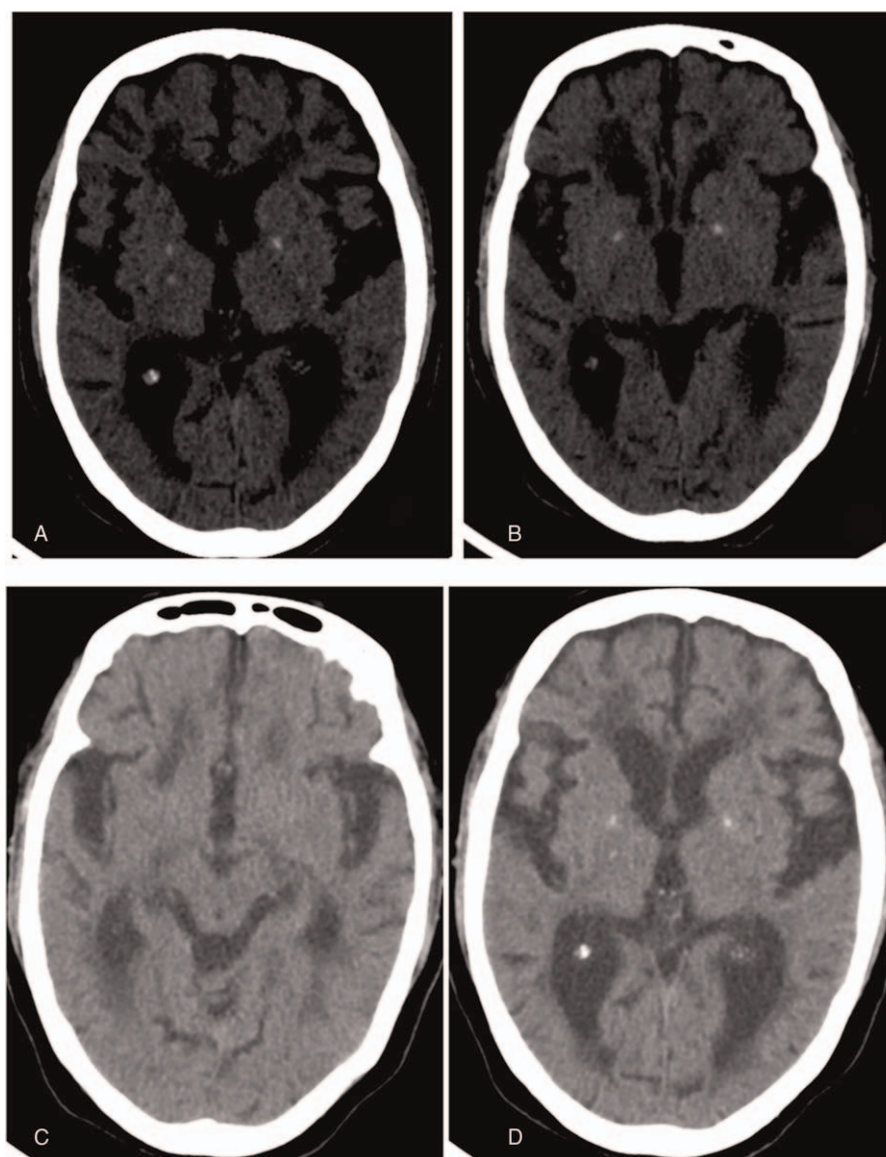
April 2015 brain CT scan (A, B): Symmetry visible image density is slightly flaky, and the bilateral basal ganglia and semioval center exhibit multiple punctate low density white matter, bilateral basal ganglia with visible symmetry punctate calcification. September 2015 brain CT scan (C, D): Bilateral symmetry visible ventricle white matter halo density changes and right basal ganglia visible low density strips. CT=computed tomography.
